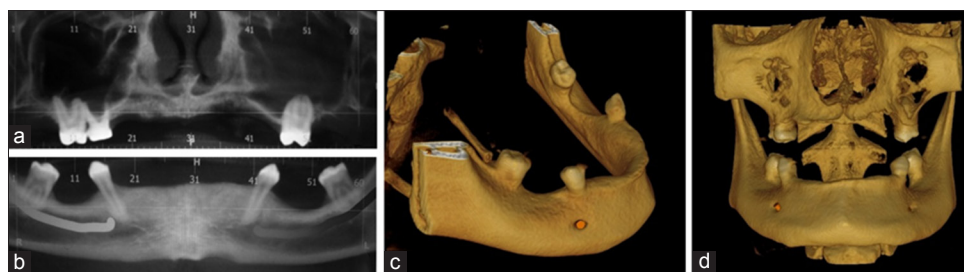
(a) Cone-beam computed tomography image showing generalized bone loss in maxilla; (b) variable amount of bone loss is evident in and around the teeth in mandible; (c) 3D reconstruction image of mandible showing knife-edge alveolar ridge in the anterior region; (d) 3D volumetric reconstruction image of maxilla and mandible
